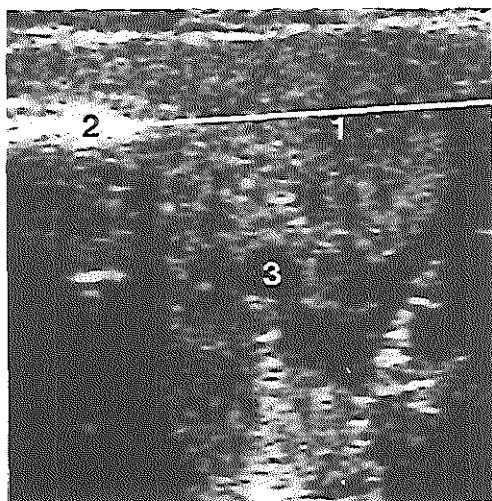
Transverse ultrasound section of the parotid gland in region II according to fig. 2. The relationship of the parotid gland to the mandible is estimated. The retromandibular vein is shown.
